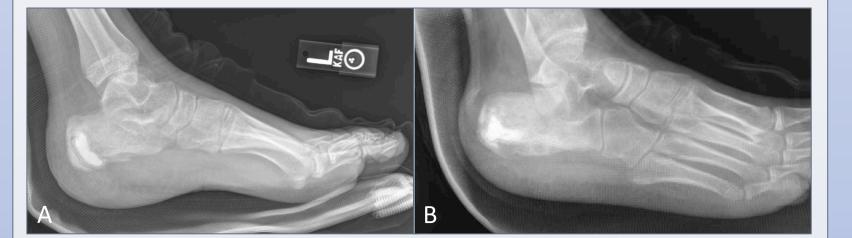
Lateral (A) and oblique (B) radiographs on date of discharge reveal early incorporation of bone filler.
